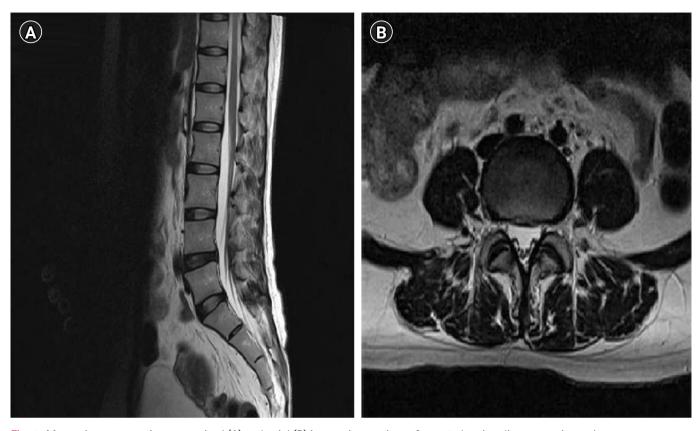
Magnetic resonance images sagittal (A) and axial (B) images in a patient of case 3 showing disc generation at L4-5.
